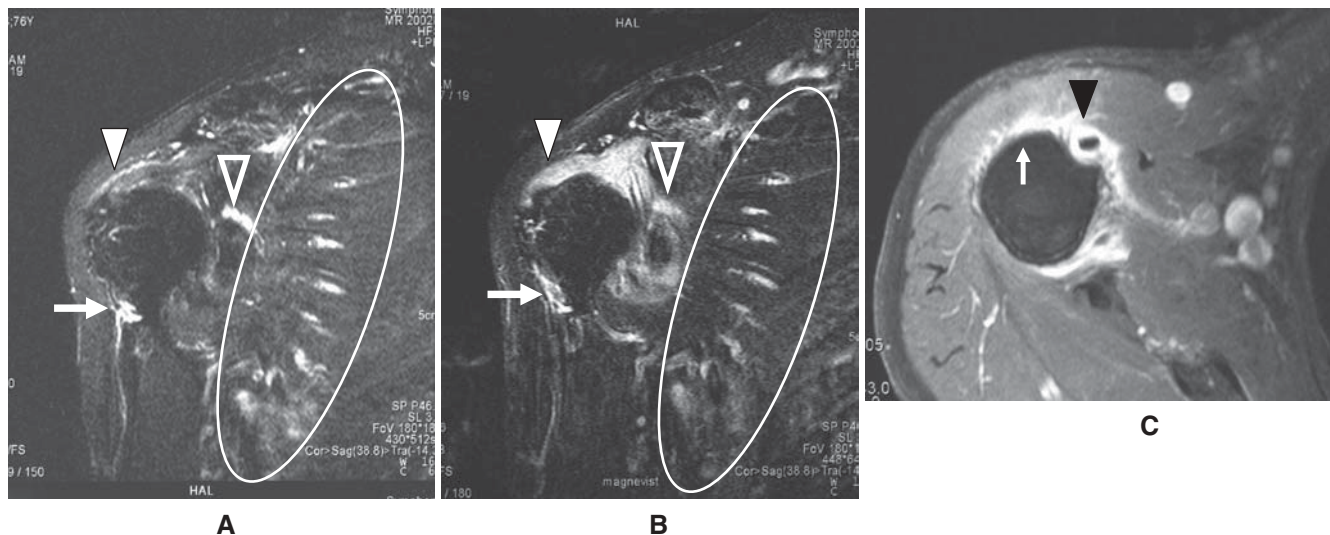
Fat suppression magnetic resonance imaging (MRI) findings of the right shoulder from a patient with polymyalgia rheumatica (PMR) and peripheral arthritis. The coronal images of fat suppression T2-weighted images (FS-T2W) (A) and contrast-enhanced FS-T1W (B) show a moderate extent of subacromial (*white arrowhead*) and subdeltoid (*white arrow*) bursitis and of glenohumeral joint synovitis
